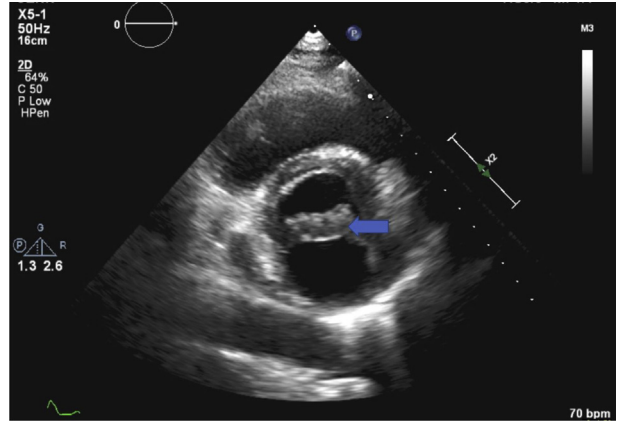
Parasternal short-axis echocardiographic view showing echodense homogenous thickening of mitral valve (arrow).
